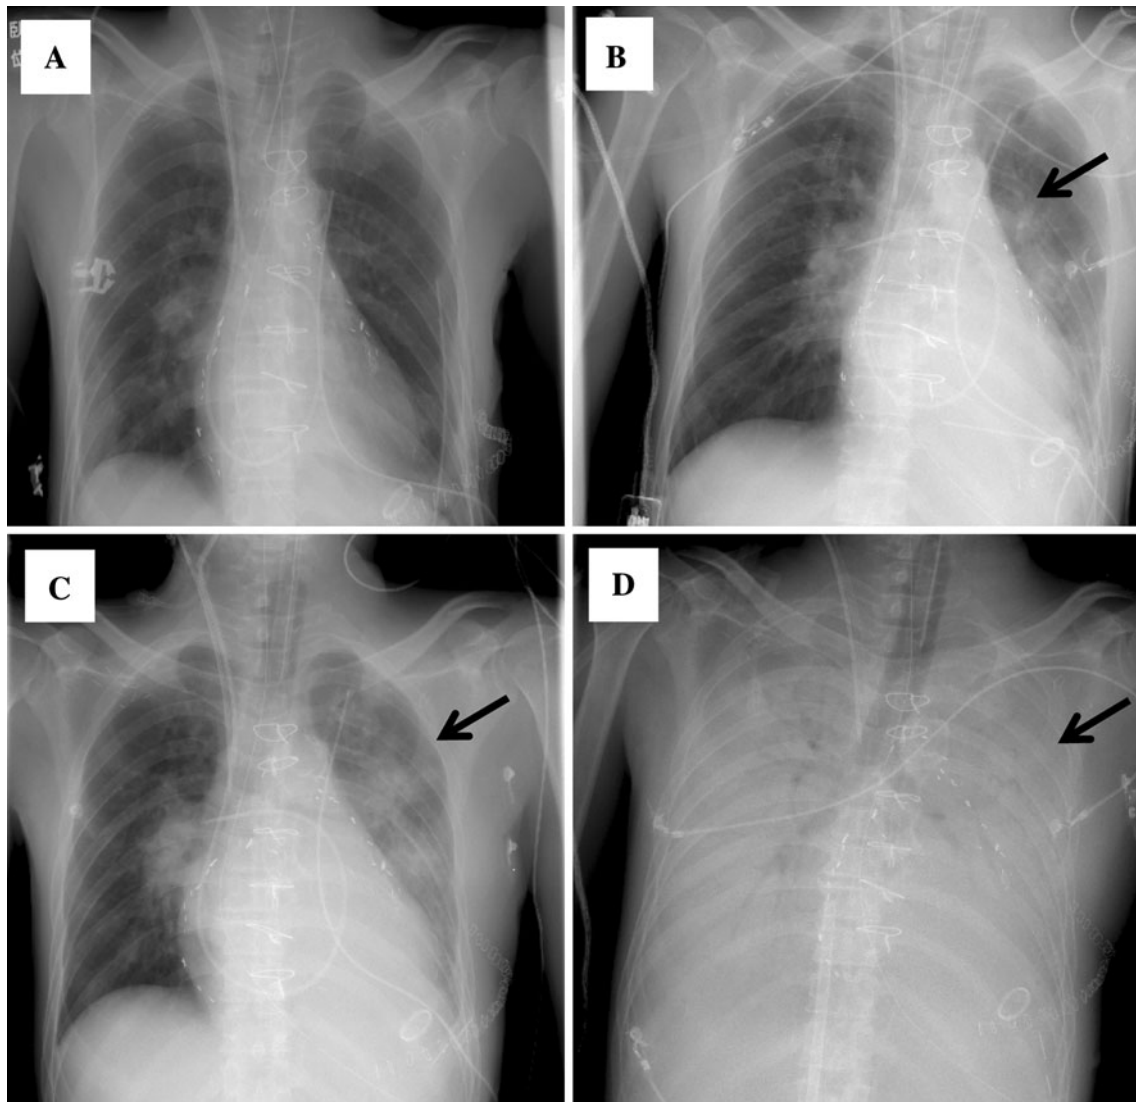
Clinical course of chest X-ray findings of a representative patient who developed pneumonia because of multidrug-resistant *Pseudomonas aeruginosa* (MDRP) after cardiovascular surgery.
